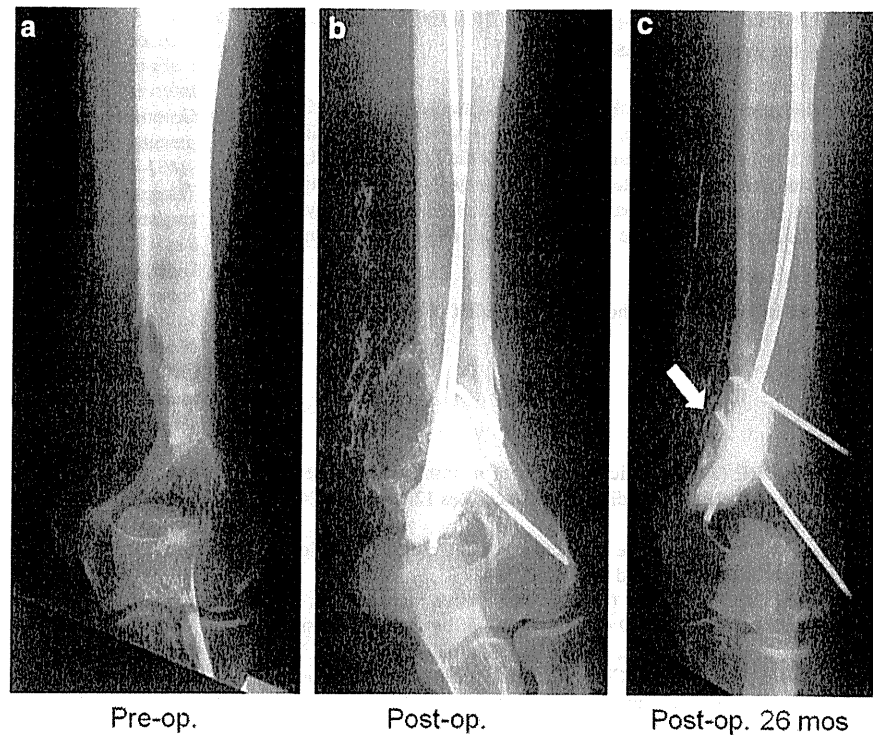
A radiograph of a hepatocellular carcinoma that had metastasized to the humerus. After curettage of the lesion followed by reinforcement with wire, CPC containing magnetite was implanted into the cavity. At 26 months after undergoing hyperthermia, no recurrence was visible (*arrow*)
